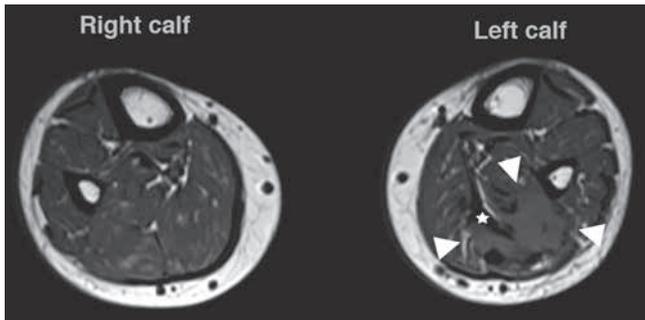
Axial T1-weighted image (WI). The lesion is denoted by white arrowheads. The central part of the lesion is of intermediate signal intensity (SI) compared to muscle. Note also the presence of bandlike areas of low SI (star). The lesion is predominantly located within the left lateral gastrocnemius muscle, but invades the soleus muscle and the medial gastrocnemius.
